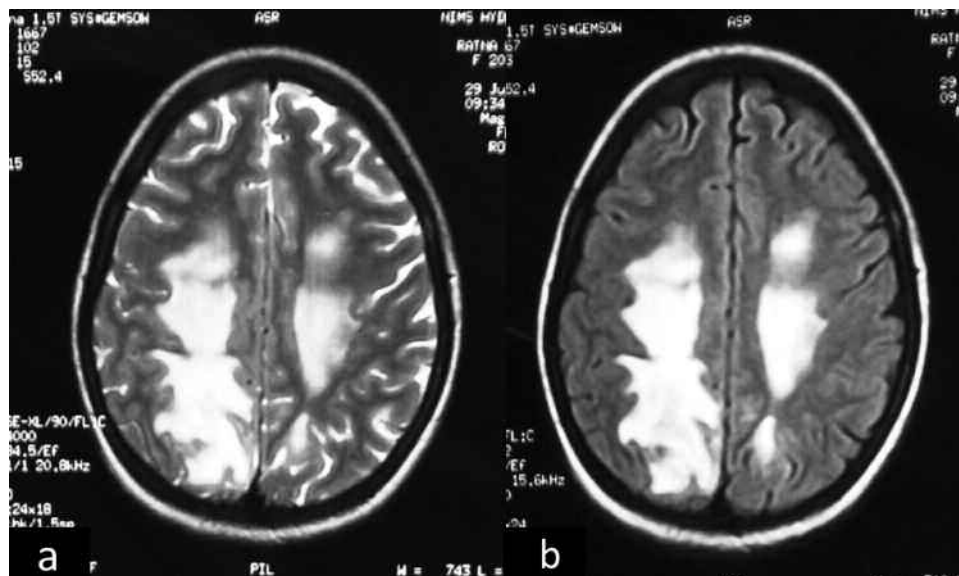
A representative brain MRI showing T2 (a) and FLAIR (b) hyperintensities in frontal, parietal, and occipital white matter.
